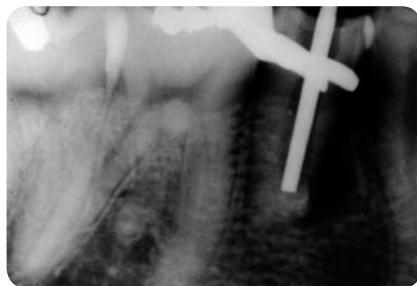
Radiographic verification of an MTA apical barrier. Note that the first molar has a third root proximal to the mesial and distal roots that appears very short.
